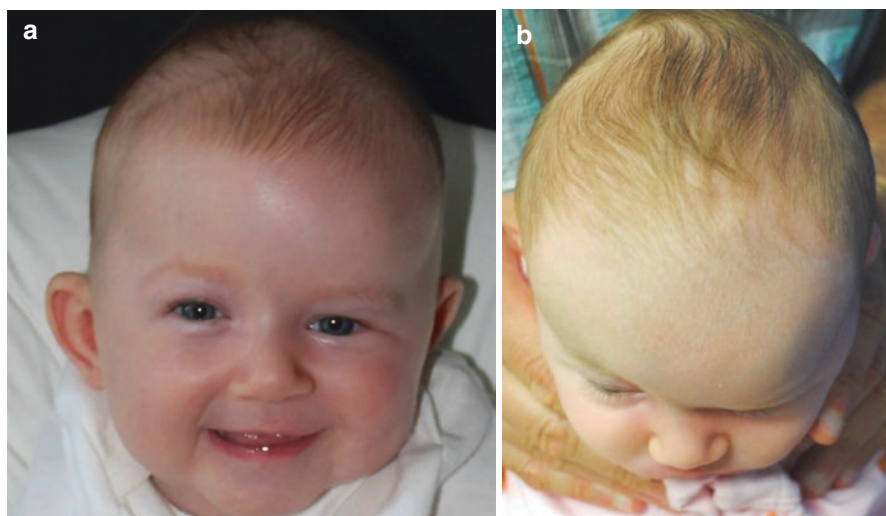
Three-month-old female with right unicoronal craniosynostosis (a, b). Preoperative CT scan (c, d). Intraoperative view demonstrating osteotomies and position of distraction device (e). Close-up view demonstrating preoperative orbital dysmorphism and postoperative resolution (f, g). Two-year follow-up appearance (h, i)
